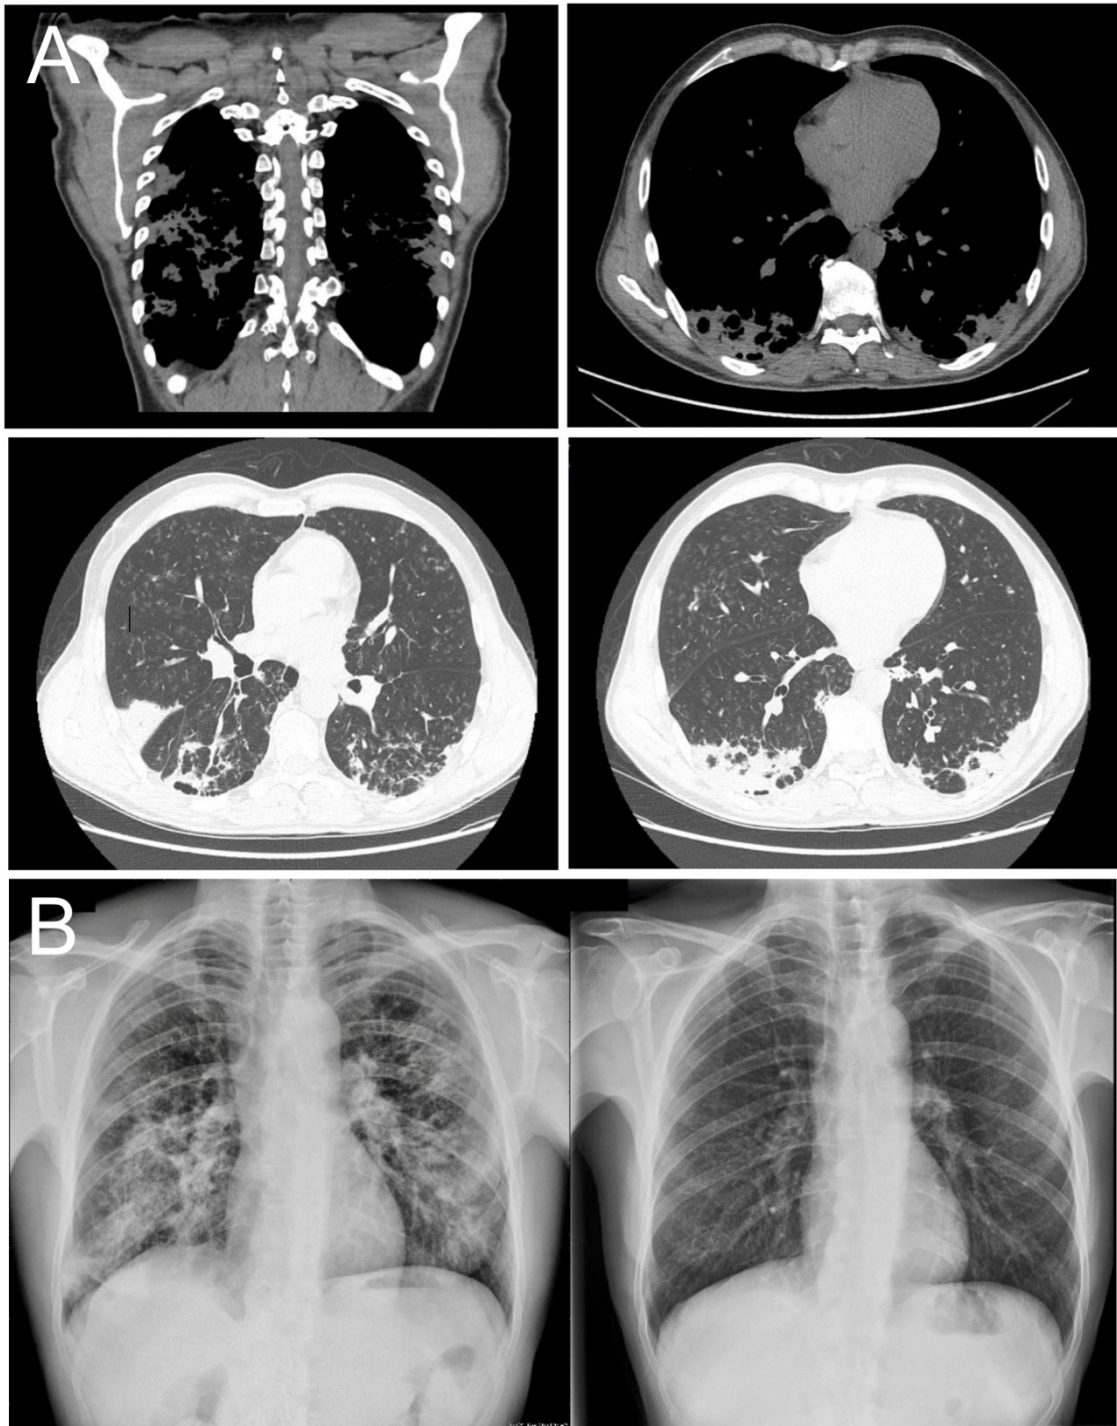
A. Thoracic CT scan. Bilateral extensive pulmonary ground-glass opacities with subpleural spare and peripheral consolidations with air bronchograms. These findings suggested subacute hypersensitivity pneumonitis. B. Chest radiographs. On the left, at the beginning of the process: bilateral interstitial infiltrates. On the right, 6 months after mesalazine withdrawal: complete radiological resolution.
